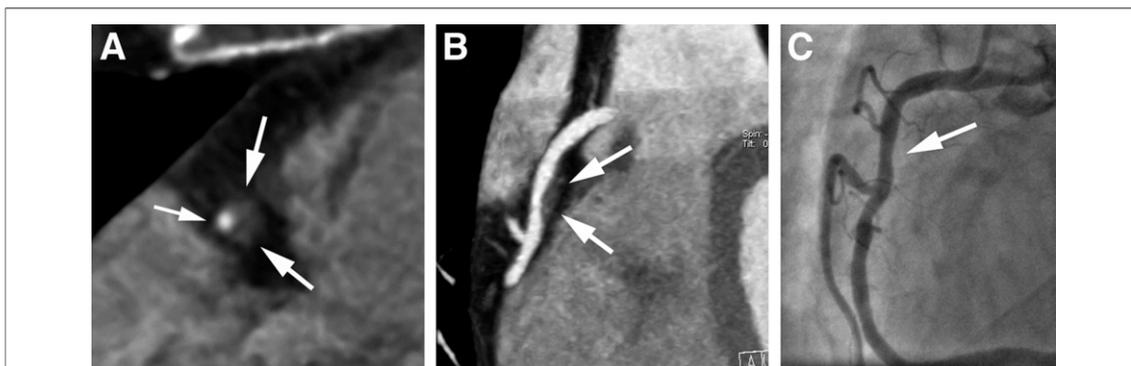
Assessing Degree of Stenosis by CT and Invasive Angiography
